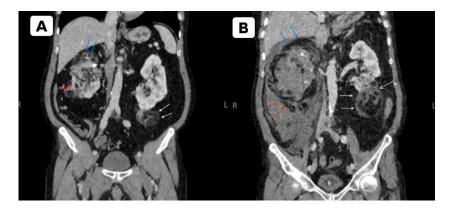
Preoperative Abdominal CT scan: (A) the coronal CT scan shows multiple fatty hypodense areas in both kidneys, consistent with angiomyolipomas that were observed 2 years earlier. The red arrow points to the angiomyolipoma suspected to have ruptured, while the white arrow indicates a large fatty hypodense area below the left kidney. (B) At admission, the CT scan shows hemorrhage caused by the rupture of an angiomyolipoma on the lower right side, indicated by the red arrow.
